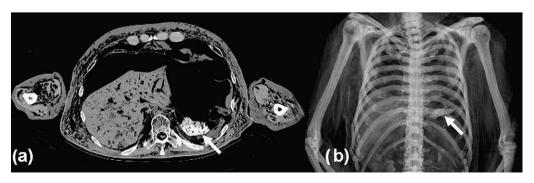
(a) Axial CT image (FoV 70 cm) shows advanced putrefaction of the body as well as a clearly hyperdense stomach content (arrow). (b) In 3D reconstruction of the chest the stomach contents appears to resemble bone in its density.
